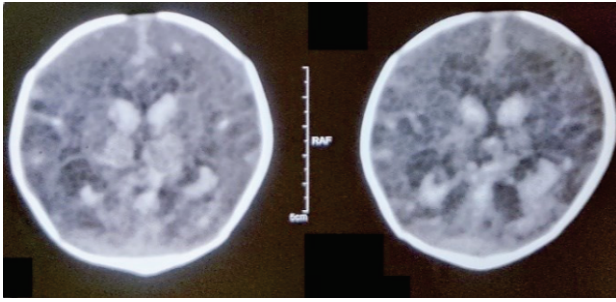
Cranial CT scan on day 8 revealing decrease in hematomas and edema
